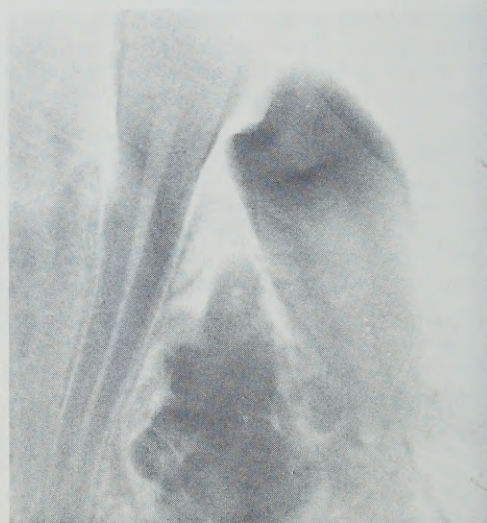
Periapical radiographic showing characteristics of a compound odontoma.
